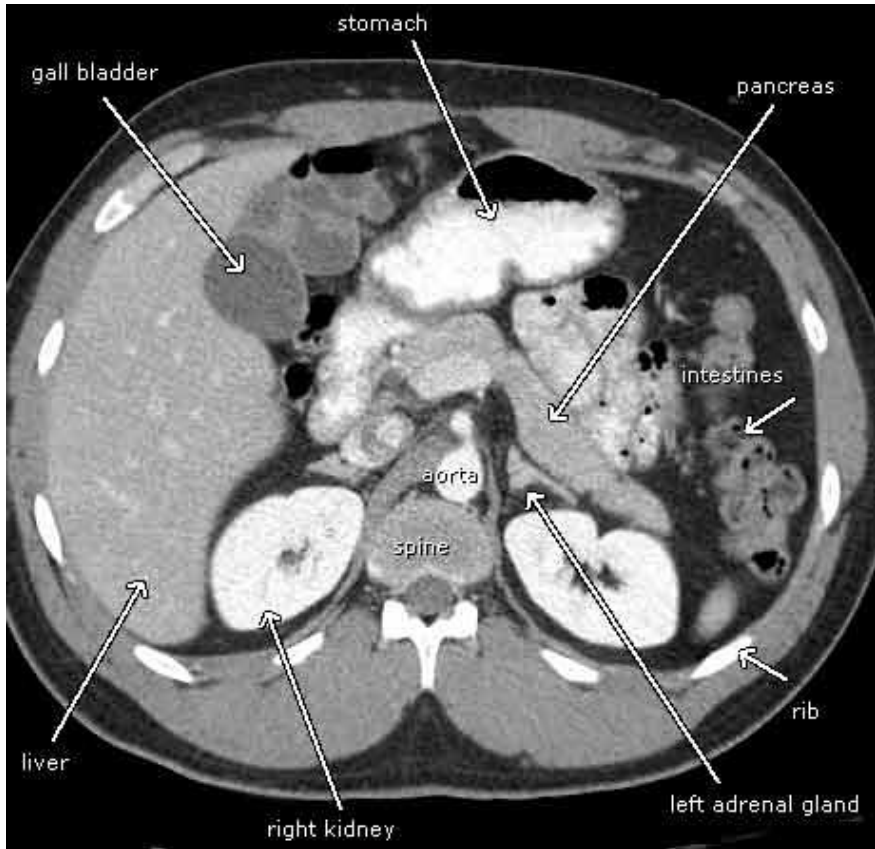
Normal liver CT
